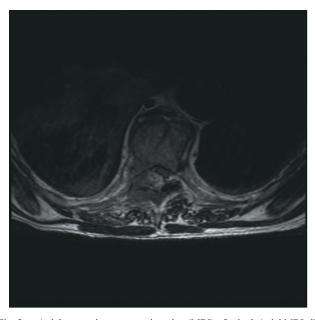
Axial magnetic resonance imaging (MRI) of spinal. Axial MRI slice at T9 level shows bone destruction, a soft-tissue mass intrudes into the vertebral canal with compressing on the spinal cord.
